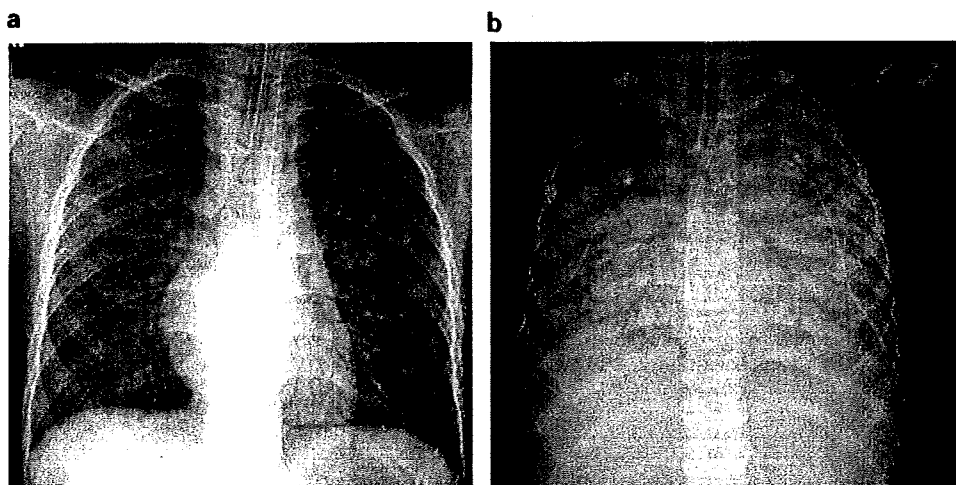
Chest X-ray films. (a) (On day 85) bilateral lung fields showed a ground-glass appearance. (b) (On day 133) bilateral lung fields showed marked radiopacity and air bronchograms.
